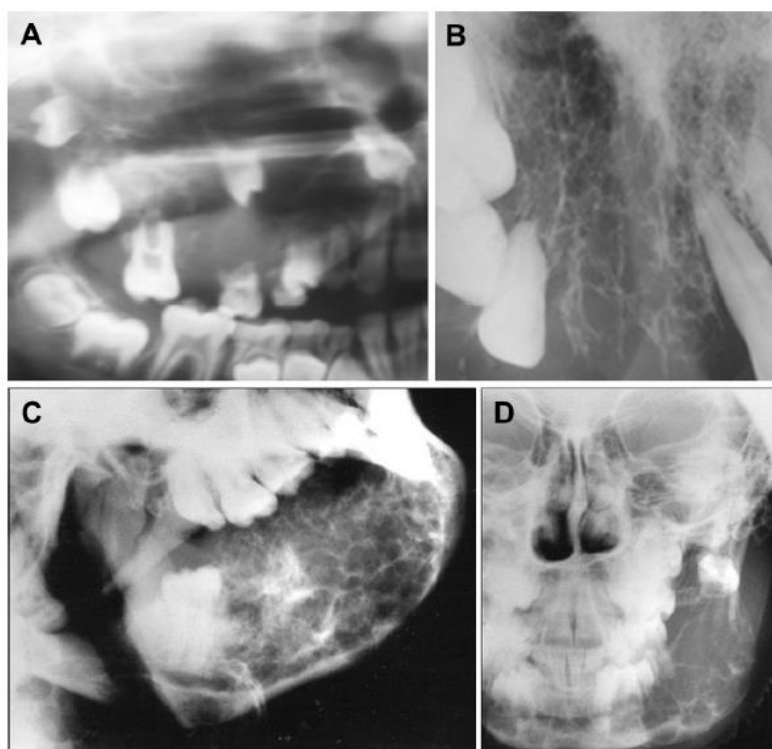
(A) Panoramic radiograph showing radiolucent lesion with no trabeculation. (B) Occlusal radiograph demonstrating a fine delicate trabecular pattern in the maxillary anterior region. (C) Lateral oblique projection showing angular septa within the lesion. (D) PA projection demonstrating the coarse trabecular pattern.
